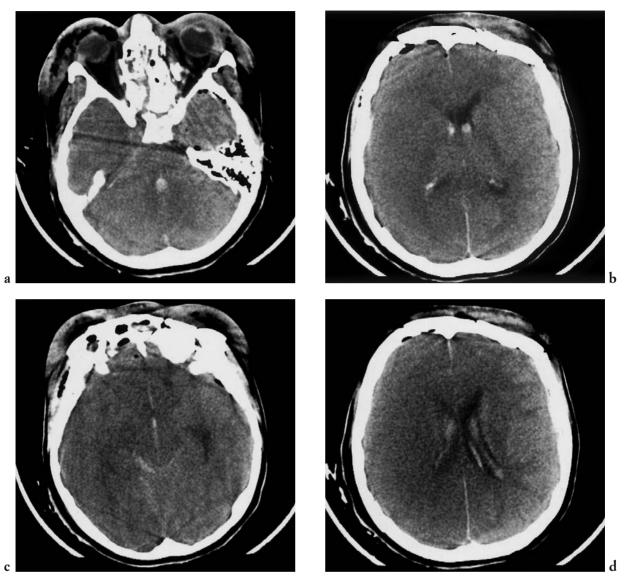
Posttraumatic intraventricular haemorrhage, pneumocephalus, and cerebral oedema. Bilateral eyelid haematomas are seen associated with subcutaneous emphysema (a). Intracranially are observed subarachnoid (b) and intraventricular haemorrhage (a), air bubbles in the CSF spaces (c) and the widespread oedema within the right cerebral hemisphere (d). [a)-d) axial CT].
